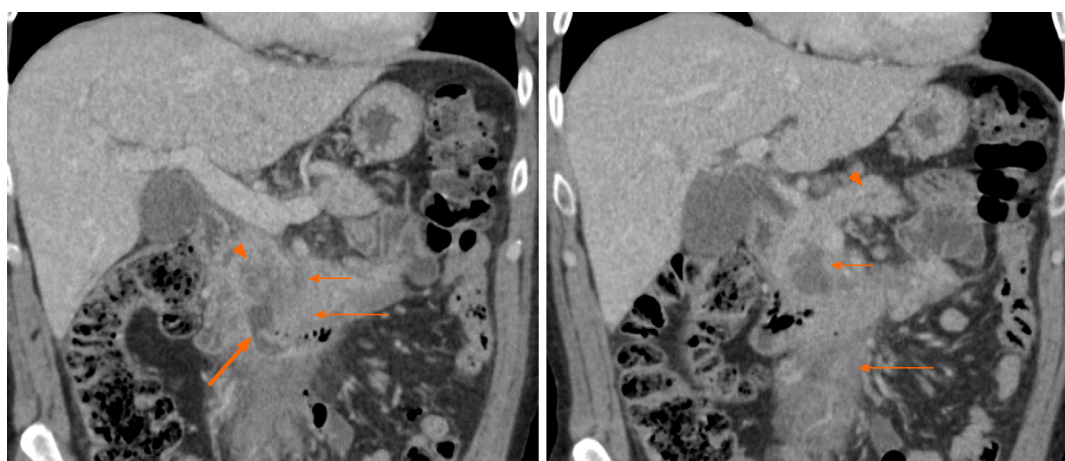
A 62-year-old male presenting with abdominal pain. Coronal computed tomography images show low-density necrosis (thin short arrow) within tumor (thin long arrow), which infiltrates the mesenteric root without occlusion of mesenteric vessels. There is a collection extending from the third part of the duodenum into tumor (thick arrow) suggesting fistula from probable erosion of duodenal wall. Mild pancreatic duct dilation is seen (arrowhead).
